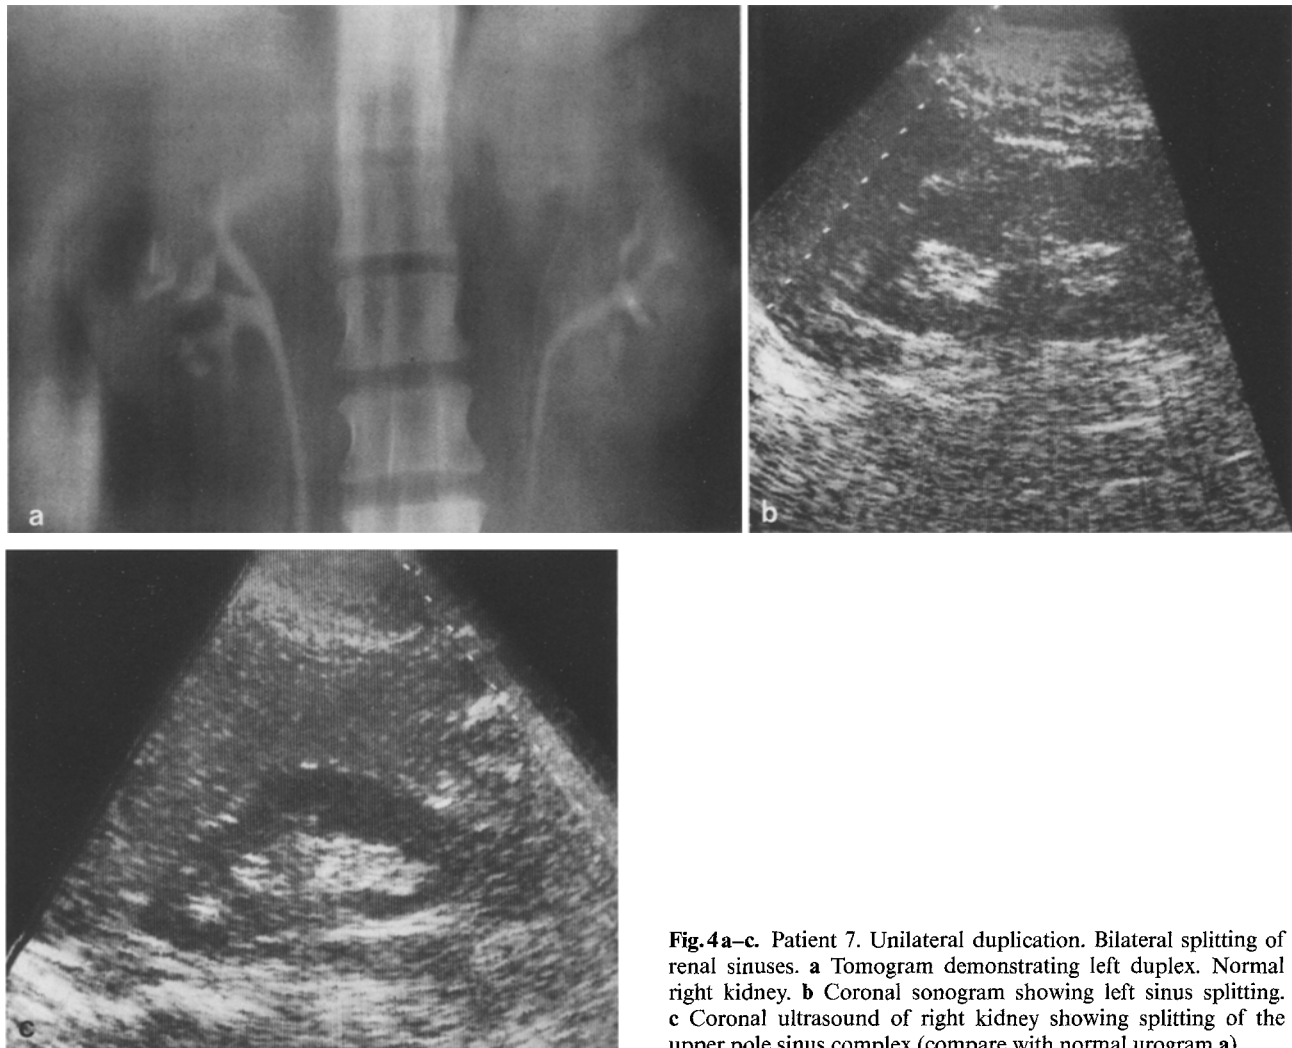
Patient 7. Unilateral duplication. Bilateral splitting of renal sinuses. a Tomogram demonstrating left duplex. Normal right kidney. b Coronal sonogram showing left sinus splitting. c Coronal ultrasound of right kidney showing splitting of the upper pole sinus complex (compare with normal urogram a)
